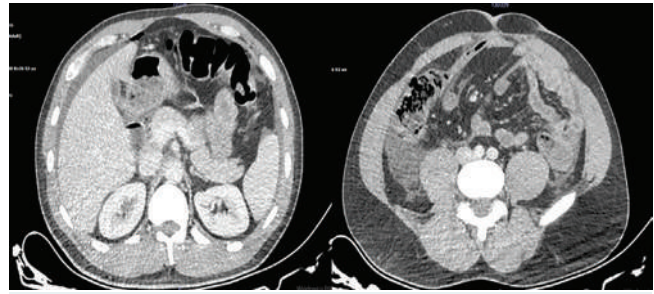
CT imaging showing free intraperitoneal air and the appendicostomy.
